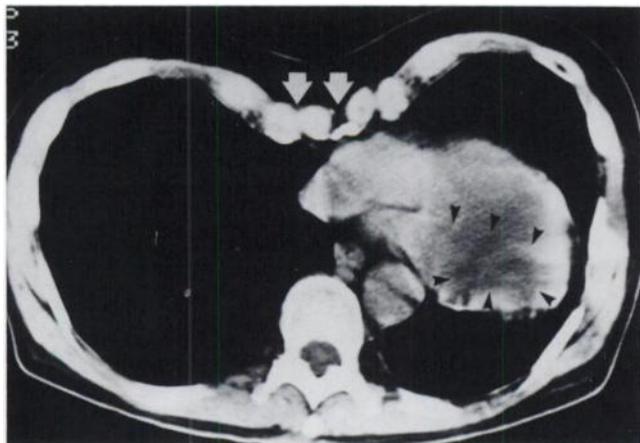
Chest CT scan demonstrates severe pectus deformity (white arrows) with marked lateral and posterior displacement of the LV (outlined by dark symbols) in the chest cavity.
